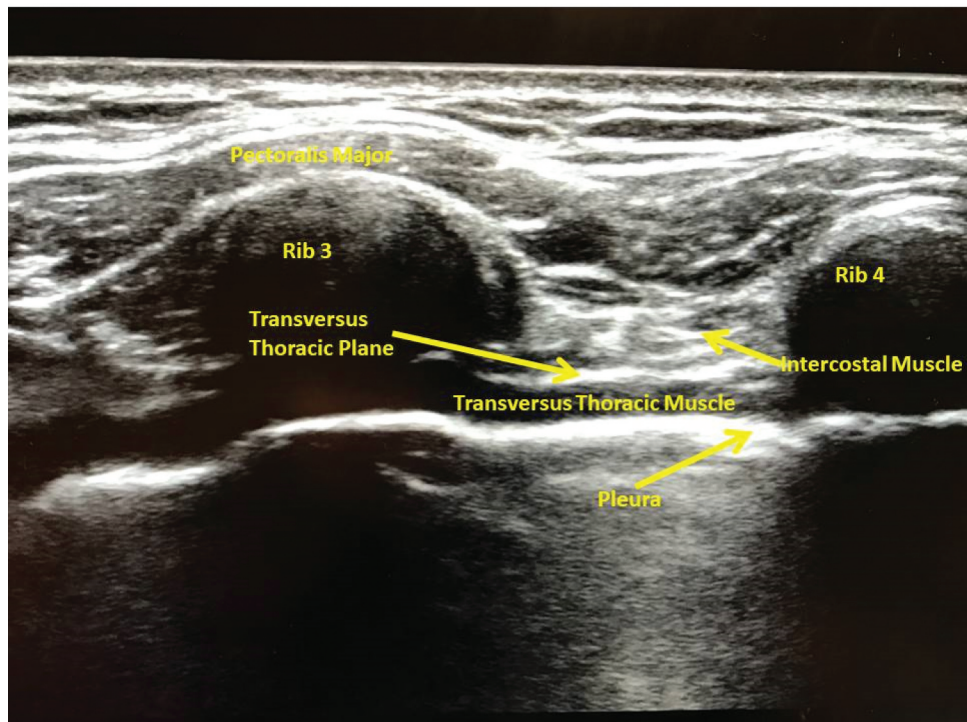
Ultrasound view of the transverse thoracic muscle plane.
